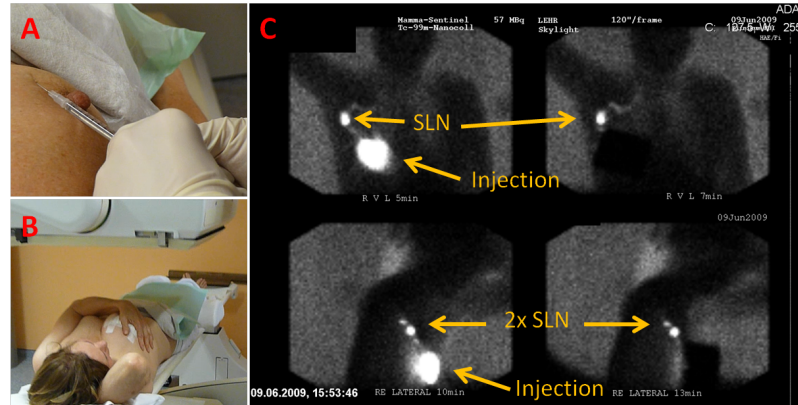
Preoperative planar scintigraphy procedure at TUM. (A) after injection, time starts running. (B) planar images are taken with 2 head cameras in AP direction, as well as lateral projection. During acquisition patient holds breast in contra lateral direction and has arm up. Camera is placed as close as possible to patient, in (B) camera is not yet finally placed. (C) shows the result for one exemplary patient with an excellent uptake and 2 clear SLNs.
